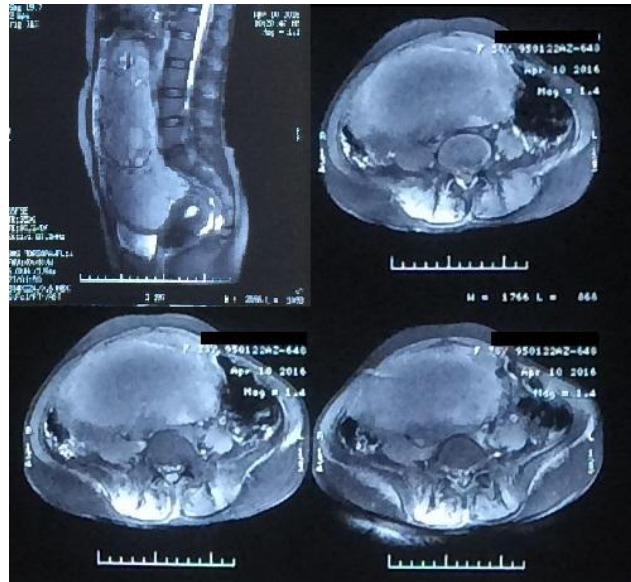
Pre-operative sagittal and axial abdomino-pelvic MRI.
